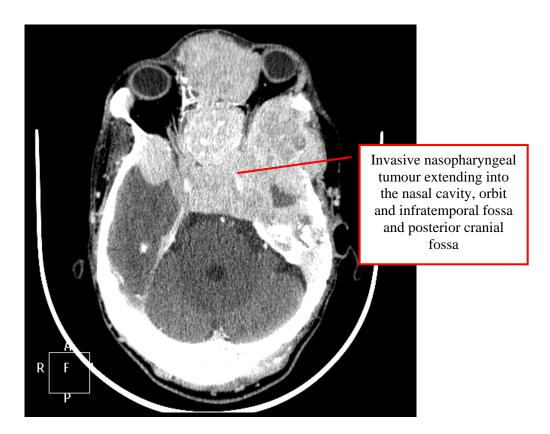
CT- Axial cut showing a malignant nasopharyngeal tumour.
